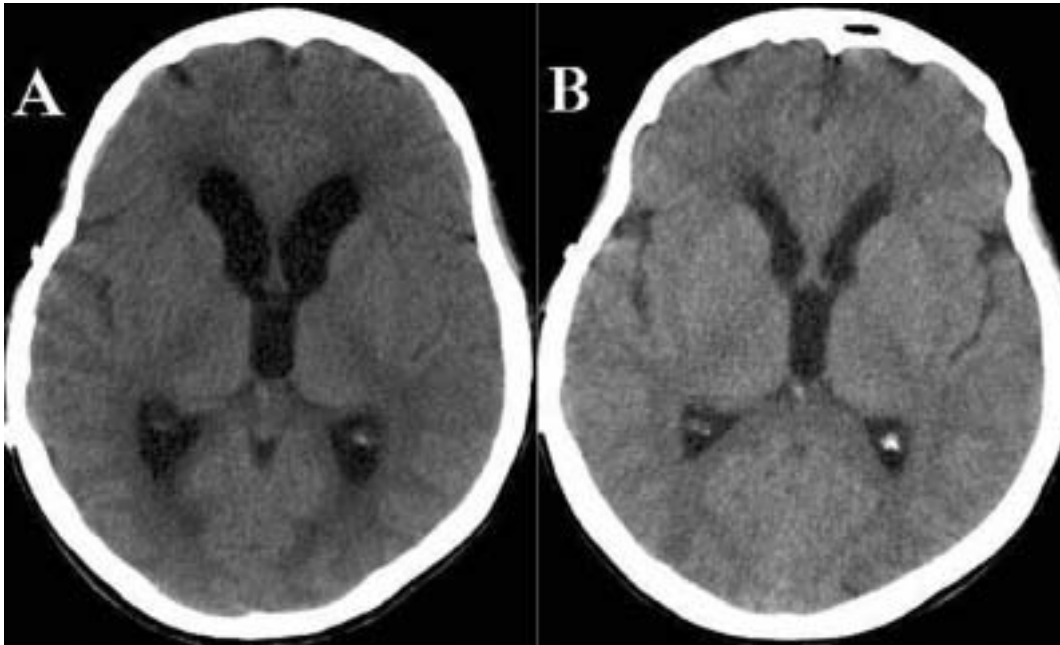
A: Head CT scan displaying ventriculomegaly obtained the day the patient developed decreased mental status. B: CT scan performed two days after externalization of the VPS demonstrating decreased ventricular size.
